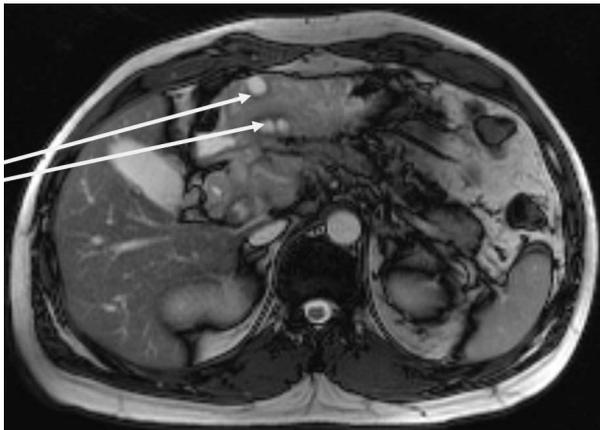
MRI showing the gastric kissing ulcers (arrows).
